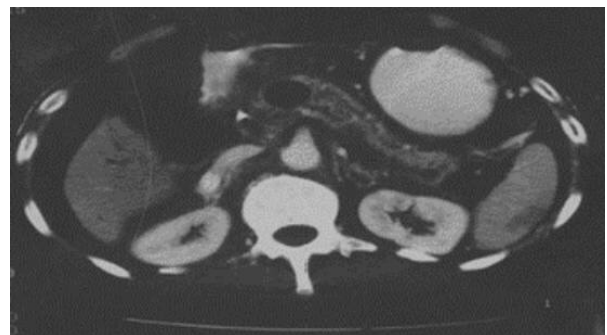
Post radiofrequency ablation contrast enhanced computed tomography demonstrating 3 cm diameter necrosed (non enhancing) area.
